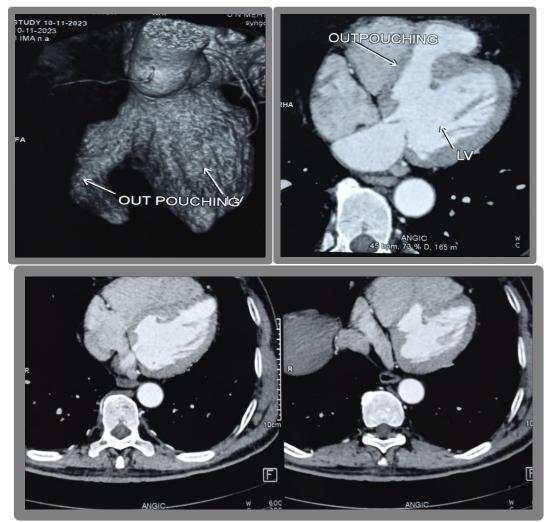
Cardiac CT scan revealed a focal contrast filled outpouching from the basal septum of the left ventricle measuring approximately 30x20x58 mm.
